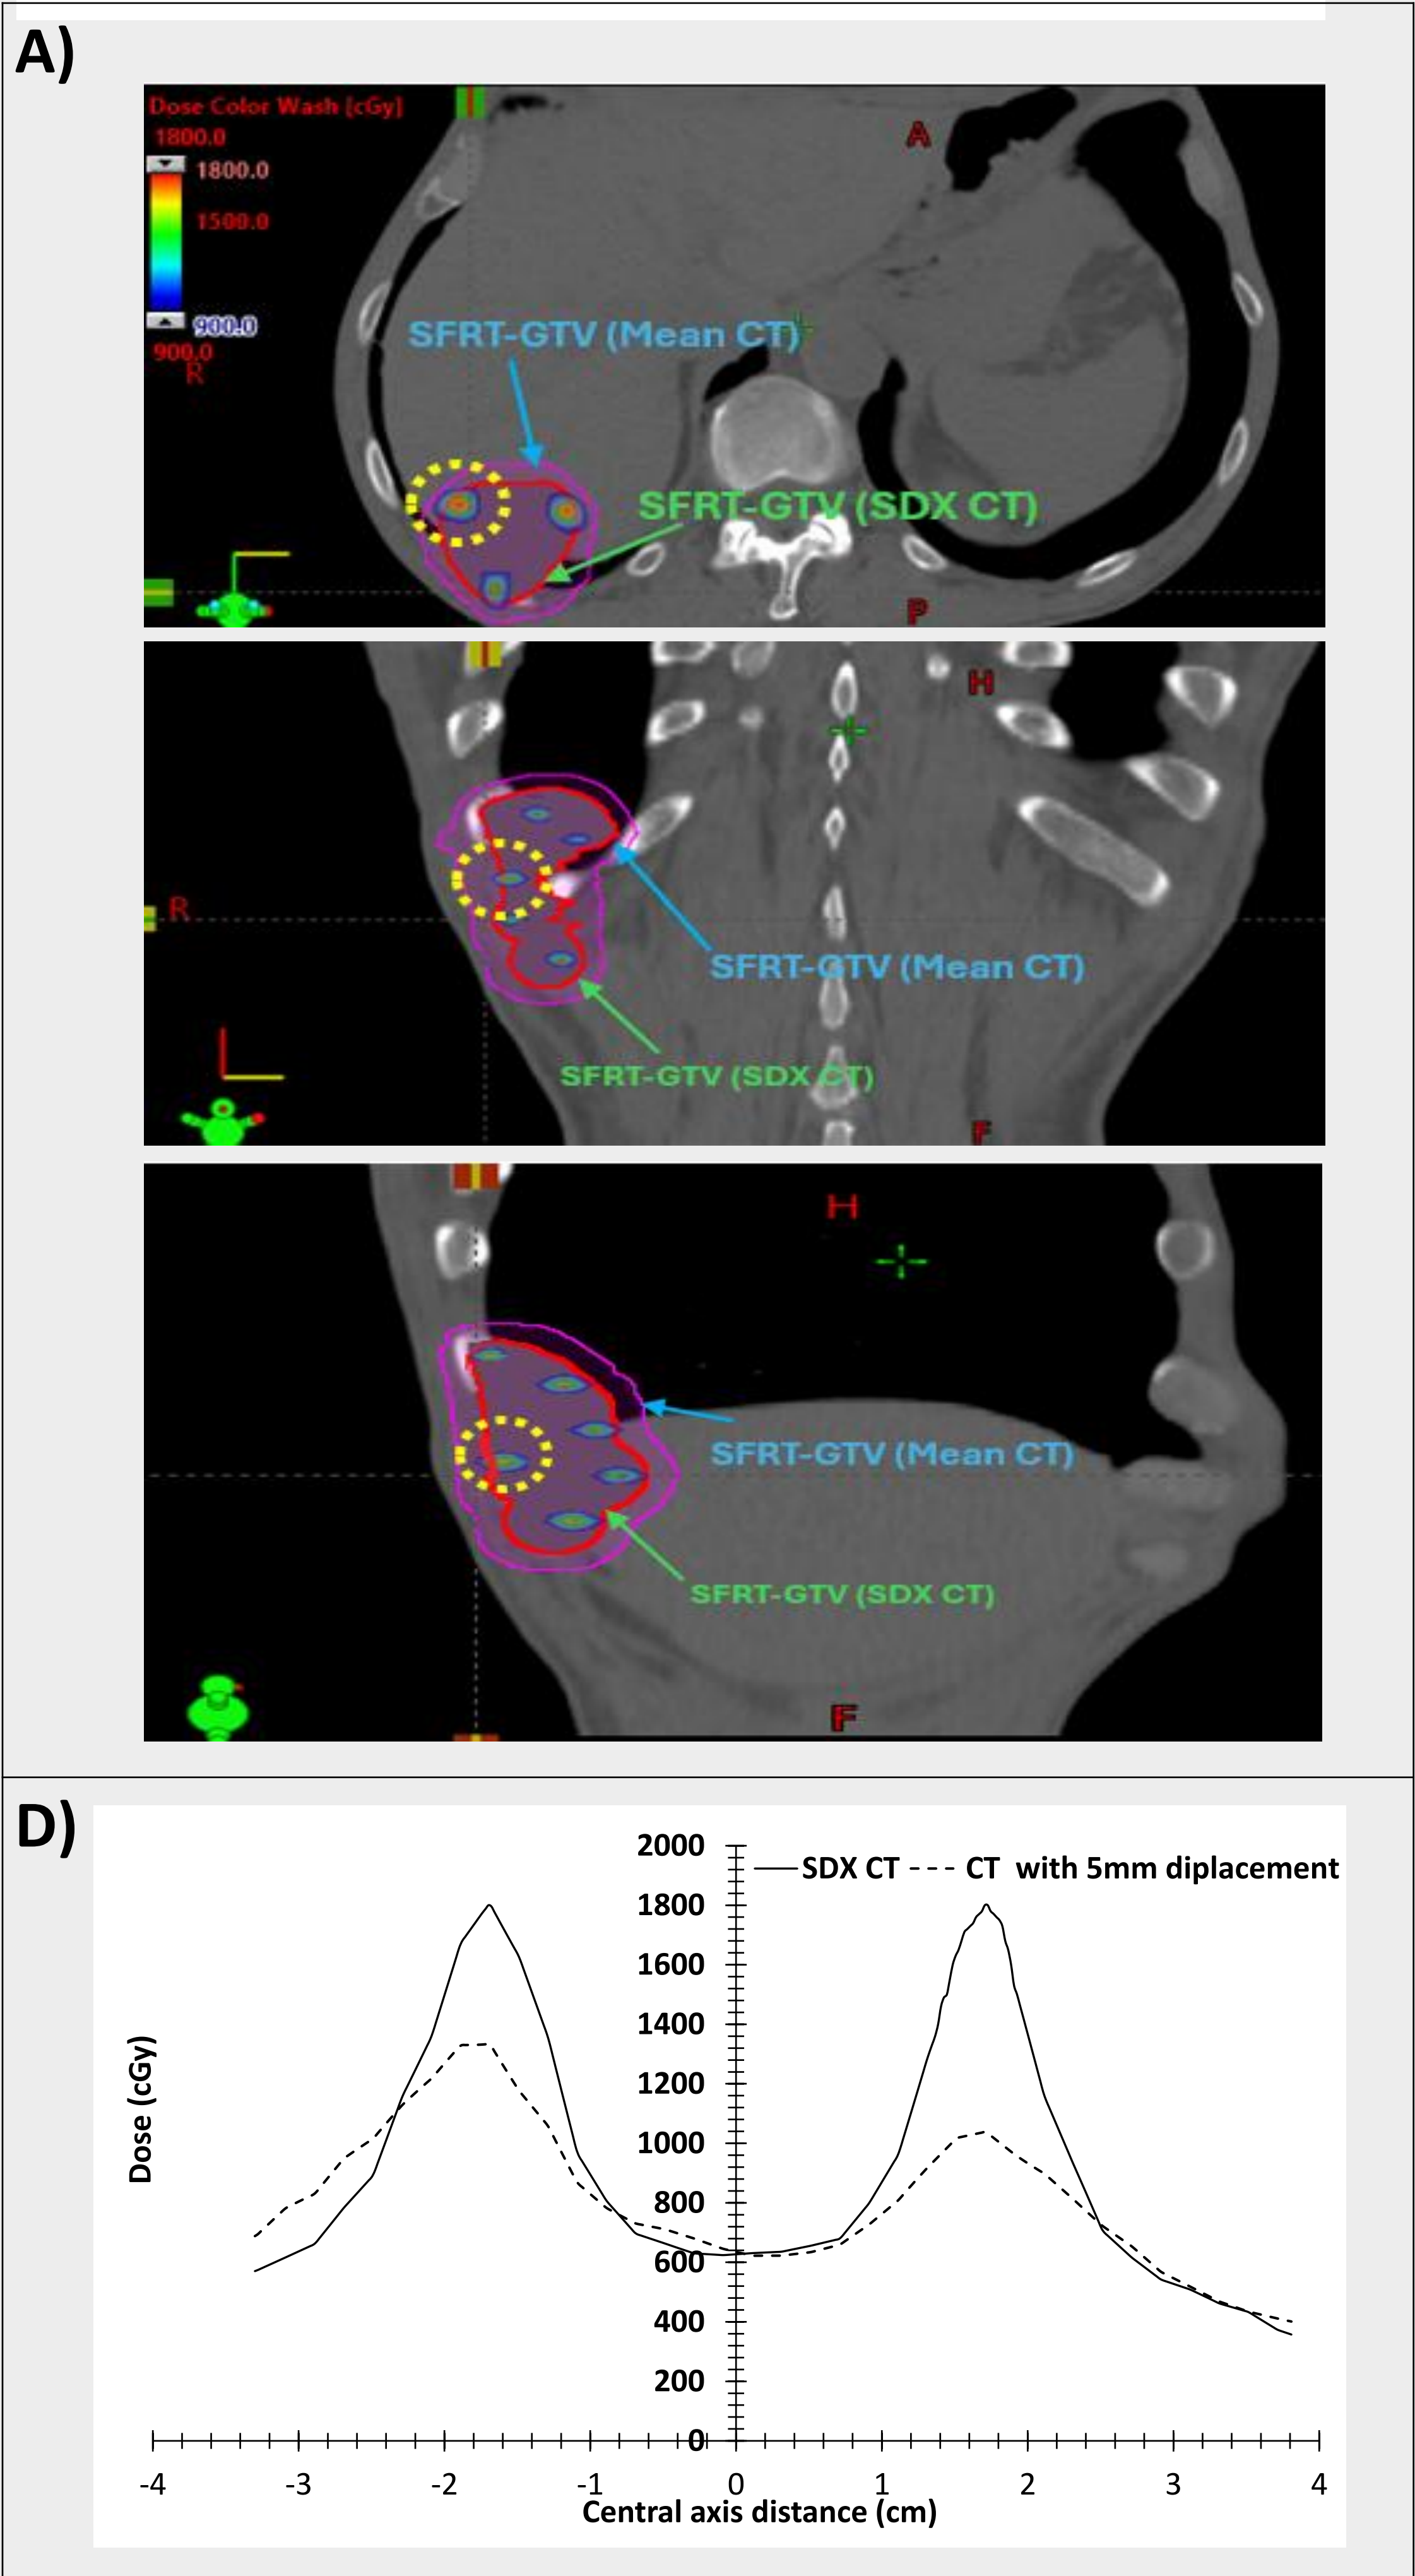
A) Axial (top), coronal (middle), and sagittal (bottom) views of the SDX breath-hold CT showing SFRT target structures. SFRT-GTV and vertex structures contoured on the mean CT were transferred to the SDX CT. Yellow dashed regions indicate high-dose vertices near or partially outside the SDX-based SFRT-GTV, highlighting potential increased dose to adjacent OARs due to respiratory-induced anatomical differences. B) Dose profile comparison along a line within the SFRT GTV on the SDX CT versus the dose profile along the same line with a 5 mm displacement in the superior–inferior direction.
